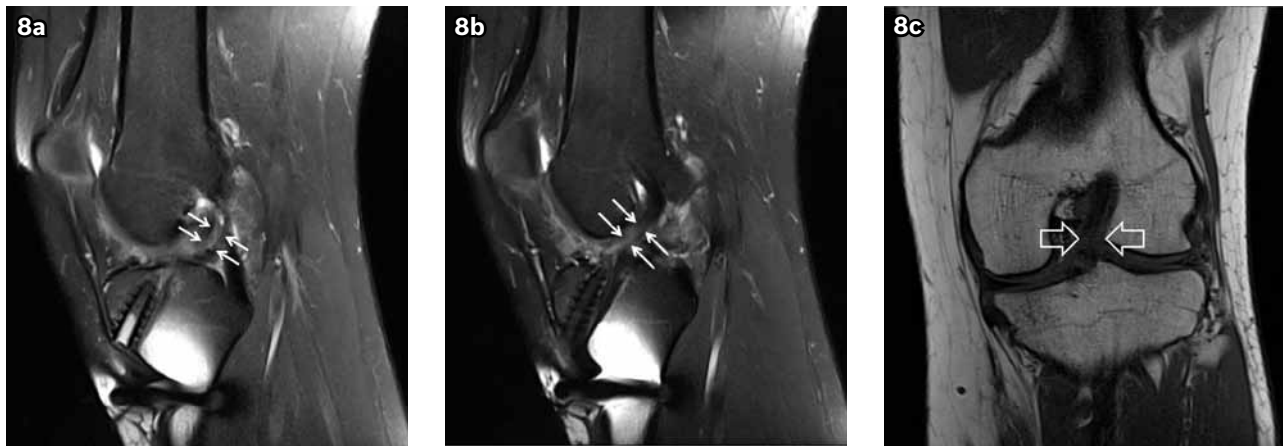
(a & b) Follow-up fat-suppressed sagittal PD-W MR images of the patient in Fig. 5 taken 18 months post-ACL reconstruction. The mid-portion of the reconstructed ACL graft is slightly angulated with hyperintense signal, in keeping with a partial tear (white arrows). (c) Corresponding coronal T1-W MR image shows a discontinuity of the normal hypointense signal in the mid-portion of the ACL graft, in keeping with a tear (open white arrows).
